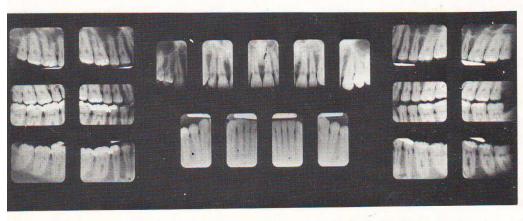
Adult complete mouth periapical survey.
